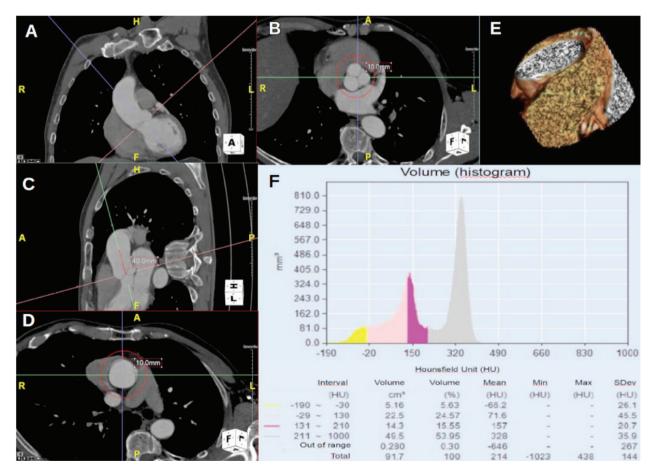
Left panels show the diameter of the ascending thoracic aorta, while right panels show the aortic peri-vascular adipose tissue attenuation chest computed tomography scan, respectively for in case 1 (A and B), case 2 (C and D) and case 3 (E and F).
